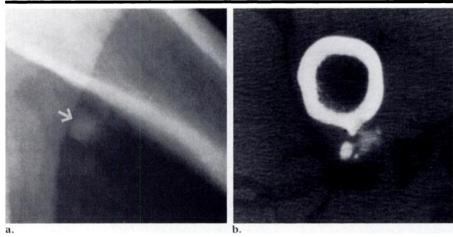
Tumoral-calcinosis-like lesion of the proximal linea aspera. (a) Lateral radiograph of the proximal femur reveals an amorphous calcification (arrow) along the posterior aspect of the proximal distal shaft. (b) CT image shows the origin of the lesion along the surface of the bone. Cortical erosion, commonly seen with this disorder, is lacking.
